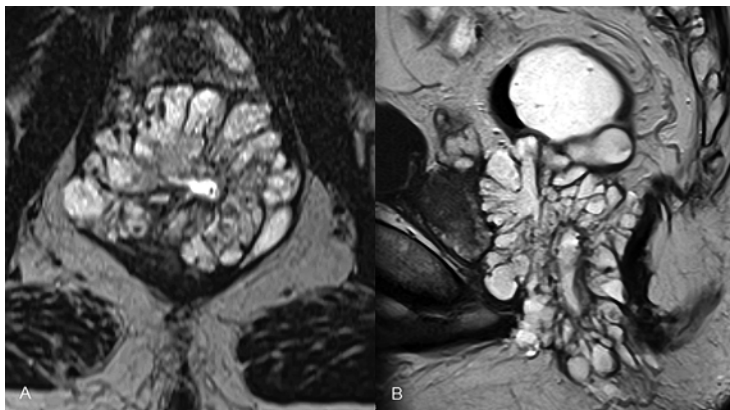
High-resolution axial (a) and sagittal (b) T2-weighted images through the lower rectum showing a large multiloculated high-signal mucinous neoplasm extending into the anal canal. Multiple thin septations within the lesion are hypointense
